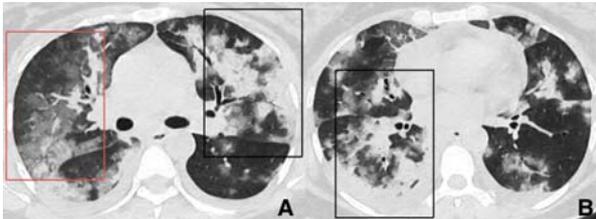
Chest CT axial images of a patient with COVID-19, with a mixture of GGO (red box in A) and consolidation (black box in A & B).
